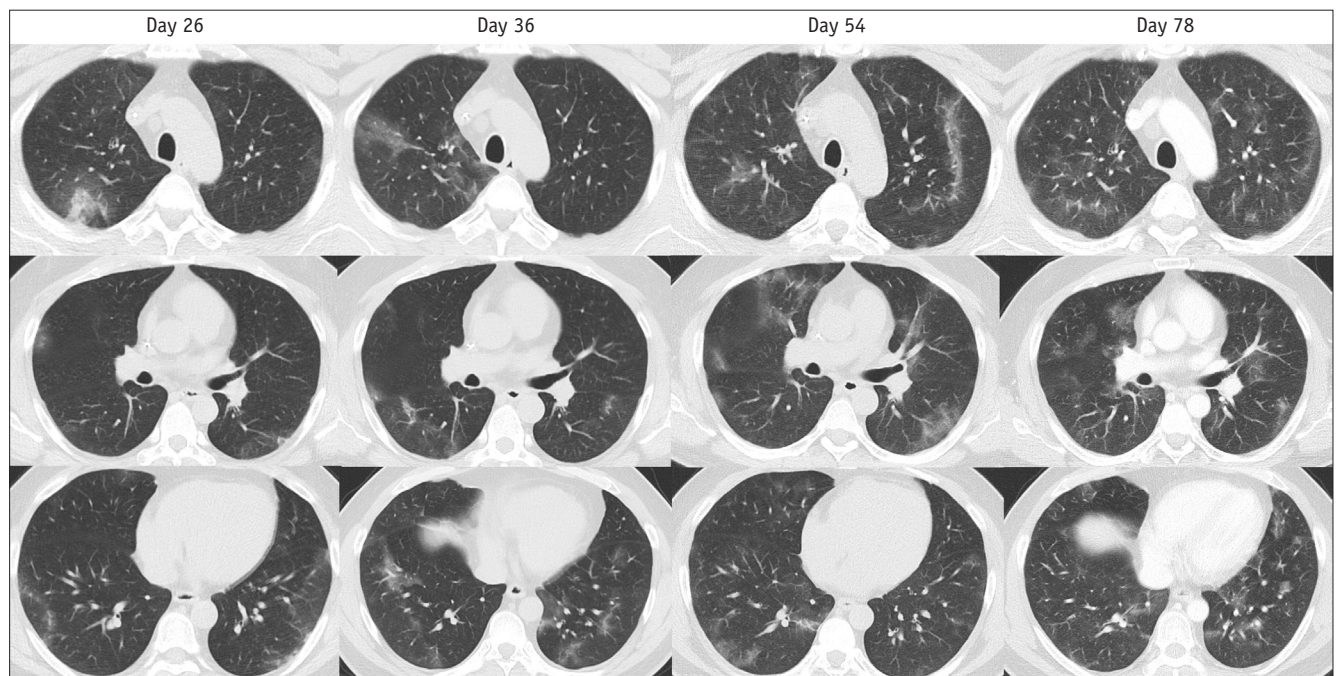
Migratory airspace opacities on serial chest CT images of a 45-year-old male (patient 5) with diffuse large B-cell lymphoma and persistent SARS-CoV-2 infection. Axial chest CT images taken on 26, 36, 54, and 78 days after COVID-19 diagnosis demonstrate migration of multifocal patchy peripheral or peribronchial GGOs, clearing of previous opacities with development of new opacities in different locations. The patient had received odronextamab, a bispecific antibody acting as a B-cell depleting agent, 9 days prior to COVID-19 diagnosis.
